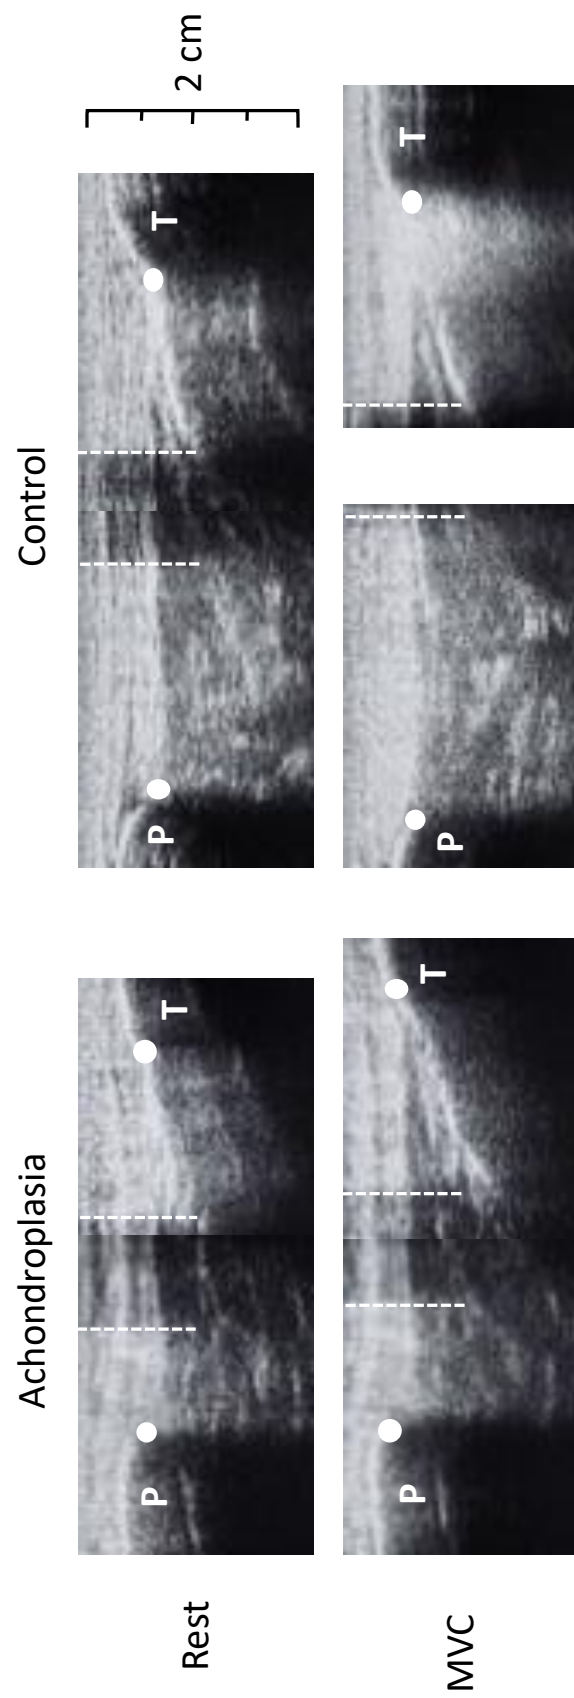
Ultrasound images during patella tendon elongation measures from rest (top) to maximal voluntary contraction (bottom) in an individual with Achondroplasia (left images) and control (right images). White dots represent the measurement of tendon length from patella tendon origin (patella, P) and insertion (tibia, T). For the longer tendons that exceed the ultrasound probe's field of view, an echo-absorptive marker was used as a reference point to help stitch images together (Onambélé et al., 2007). The boundaries of the marker are identified by the white dotted lines.
